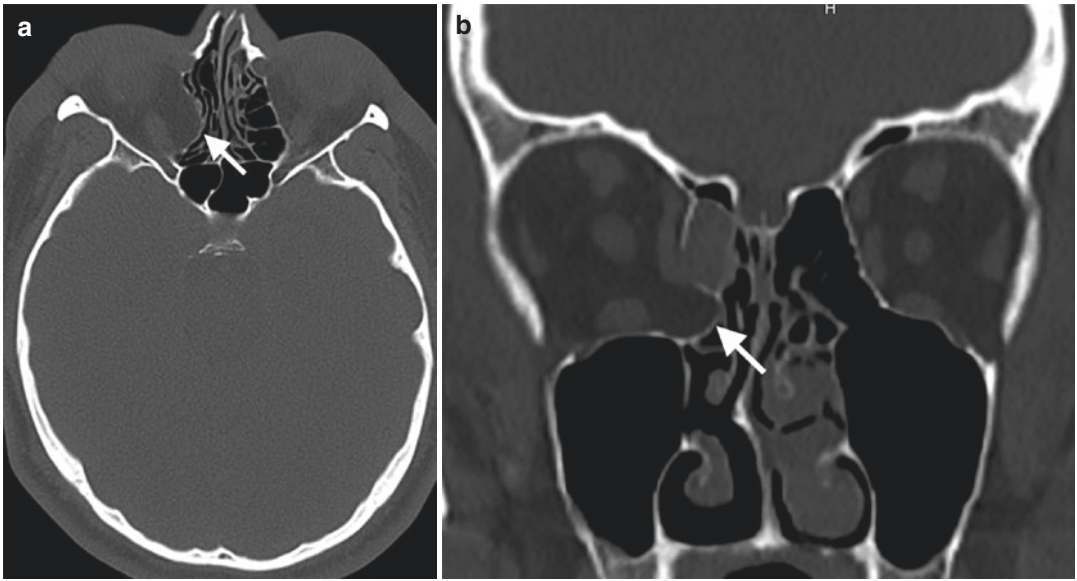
Axial (a) and coronal (b) CT images of a patient reveal dehiscence of the right lamina papyracea (arrows) that mimic blow-out fracture of right orbita. No medial
